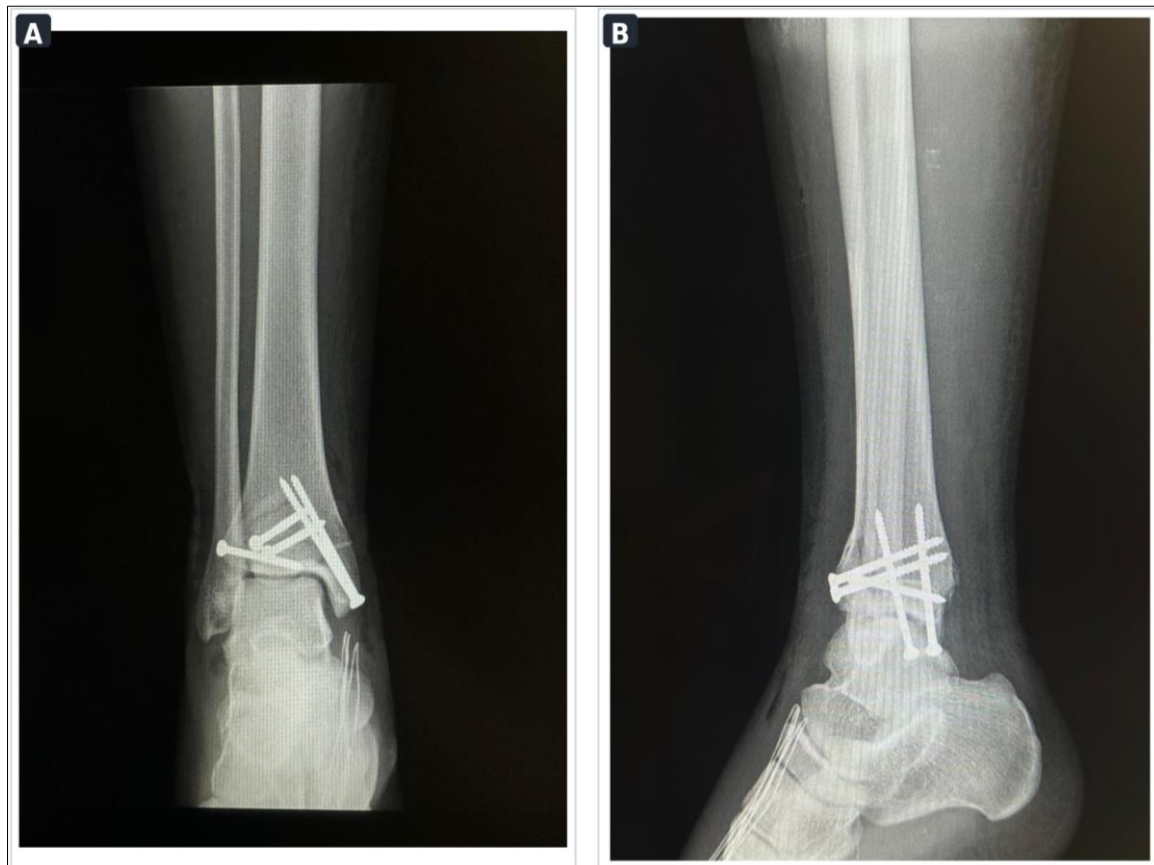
Immediate postoperative radiographs. A: anteroposterior view. B: lateral view. The construct comprises five cancellous screws, with satisfactory maintenance of reduction and appropriate implant positioning
